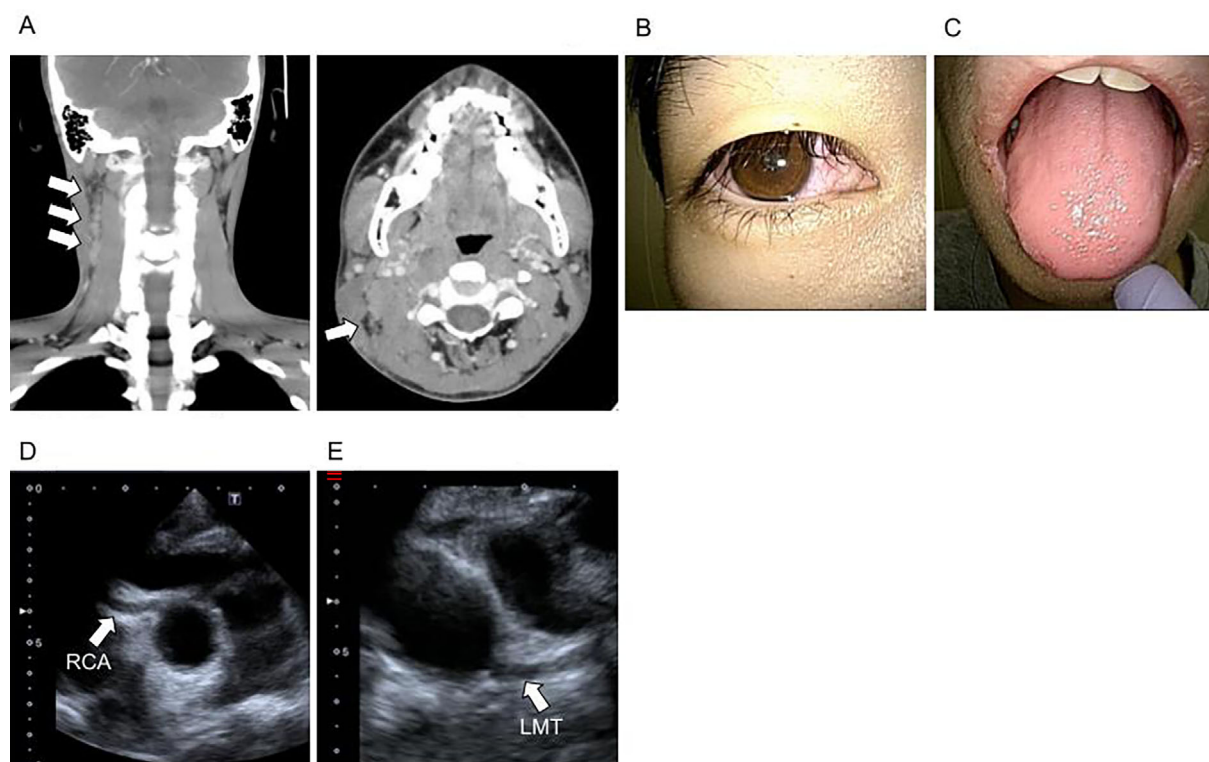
Findings of the case 1 at admission. A: Neck CT with right lymphadenitis. B: Conjunctival hyperemia. C: Strawberry tongue, and injected lips. D: TTE: RCA. E: TTE: LMT.
